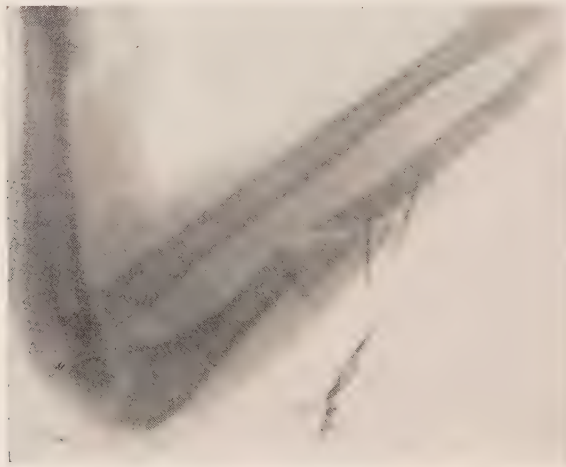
Comminuted fracture of the shaft of the ulna. (Roentgenogram by Dr. G. C. Bird.)
